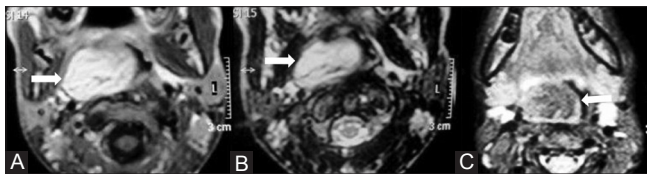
(A-C): Axial MRI images of neck shows T1 and T2 hyperintense mass lesion in the right pharyngeal mucosal space (white arrows) (A, B) with suppression of hyperintense signal in the fat-sat sequence (C) confirming the fatty nature of the lesion
